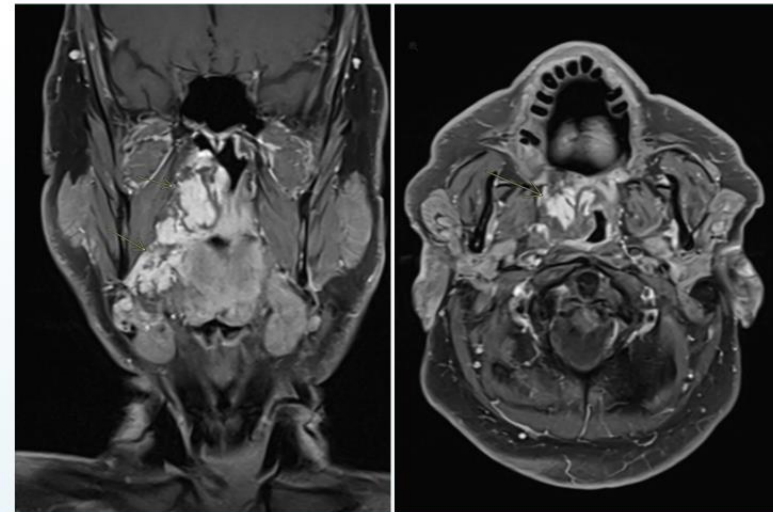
displays a T2 FLAIR MRI scan.
